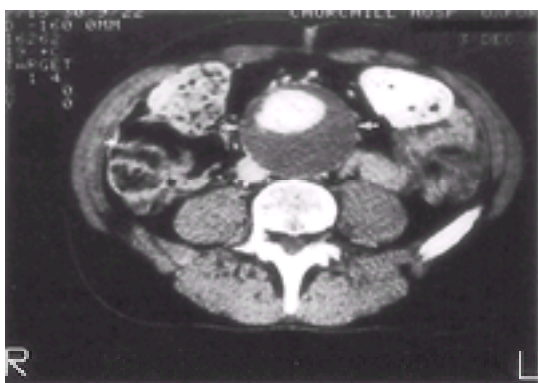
CT scan of a large abdominal aortic aneurysm, showing mural thrombus.
